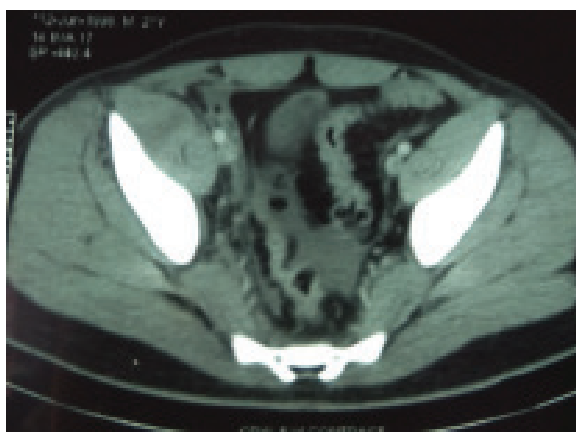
Computed tomography scan showing right sided iliopsoas haematoma
